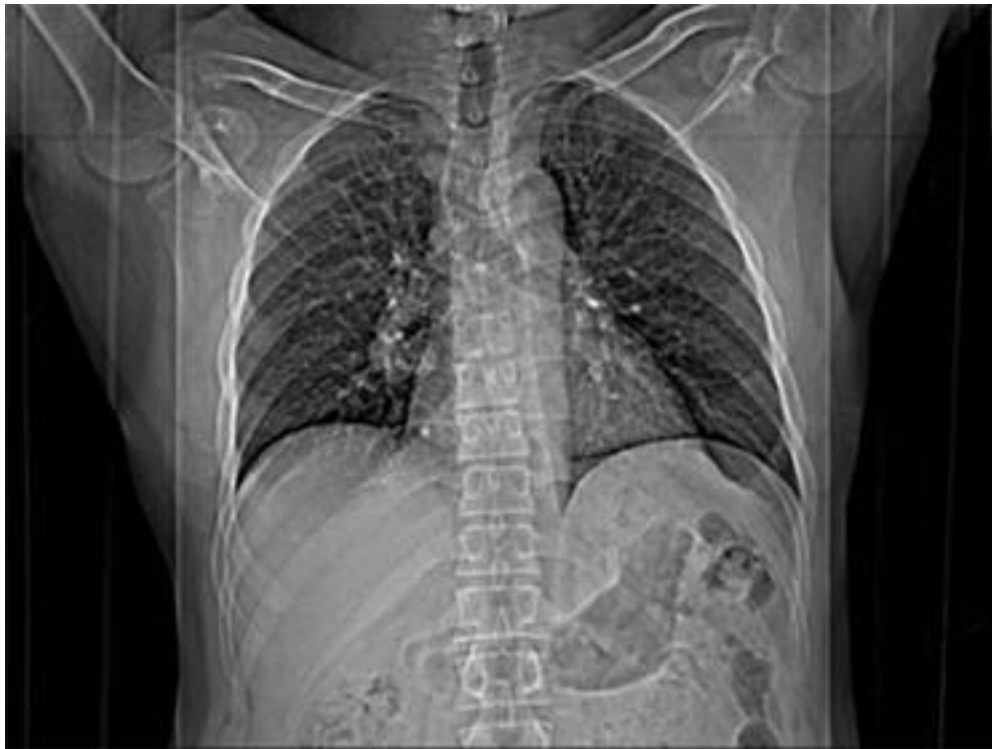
Figure CTA-1: Example image of chest topogram
